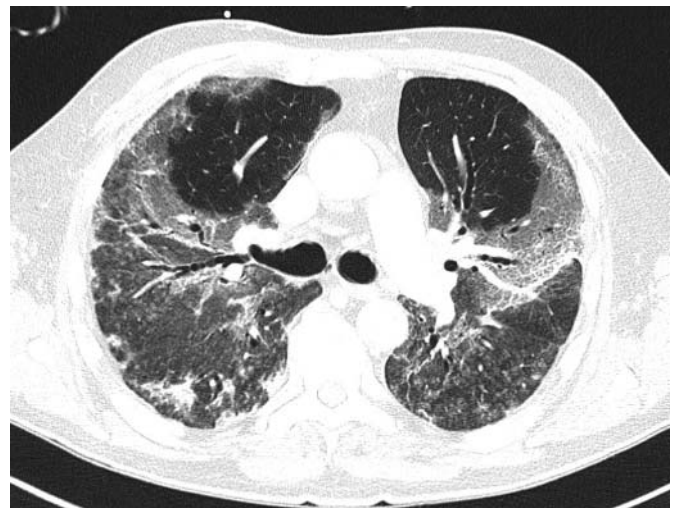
Chest computed tomography with several signs of diffuse parenchymal lung injury including extensive ground-glass opacities and micronodular changes.
